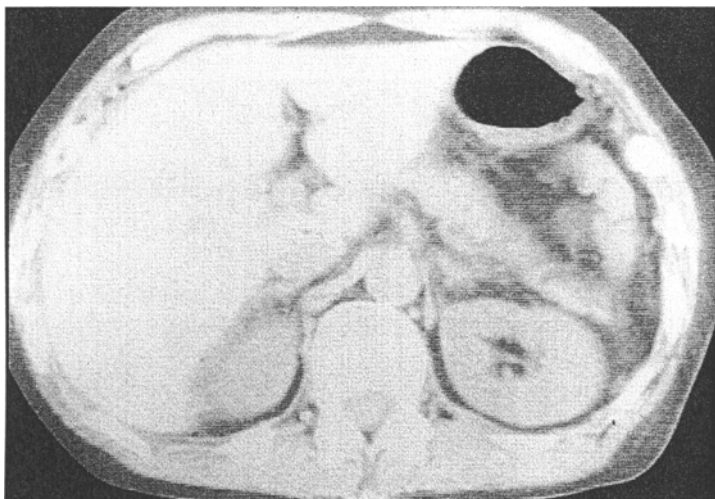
50-year-old woman with perforation of diverticulum of sigmoid colon. Left, there is no free air around the liver. Right, lower CT image reveals typical finding of dirty mass (arrow).
